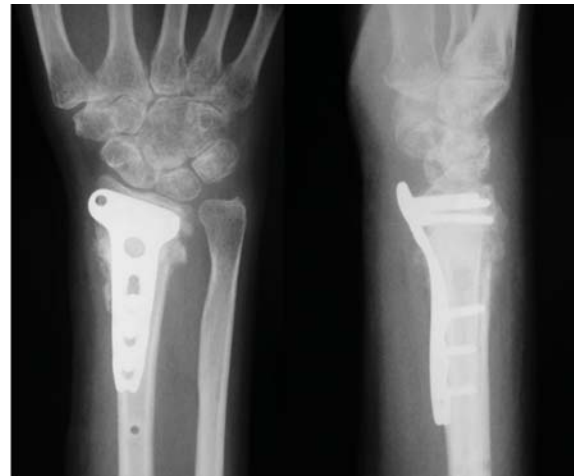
Postoperative posteroanterior and lateral radiograph reveal an acceptable alignment of the distal radius. The plate was distally placed. The gap between the distal portion of the plate and radial styloid is noted
